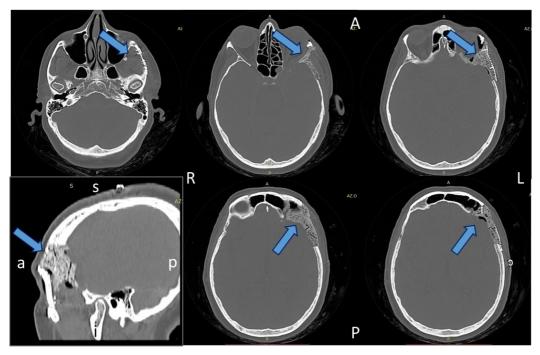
First follow up time point 11 days after surgery. The arrows indicate the graft. CT scan (without contrast) 250 mA, 120 kV.
